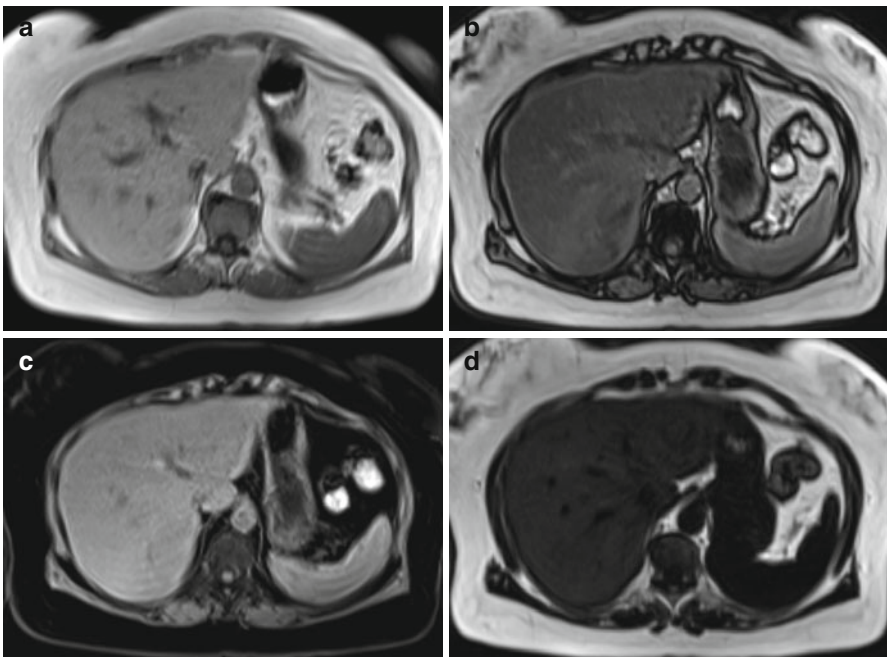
A 56-year-old obese female subject. Chemical shift-encoded MRI allows determination of liver fat. (a, b) Signal intensity drop on out-of-phase images demonstrates diffuse fatty infiltration of the liver. Supplementary fat-saturated (c) and water-saturated (d) images confirm the diagnosis of hepatic steatosis
